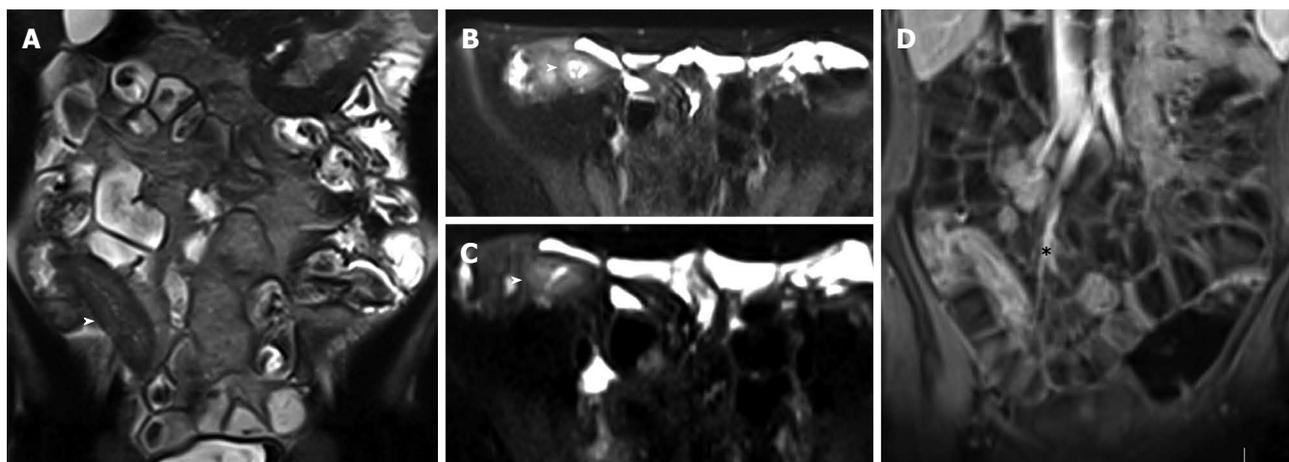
Thirteen years old male with active Crohn's disease. Coronal T2-weighted image (A), and transverse fat saturation T2-weighted images (B and C), show mural thickness and increased mural signal (arrowhead in B, C, and D) in the terminal ileum due to edema. Coronal post-contrast T1-weighted fat-suppressed image (D) at the same level shows mural stratification (asterisk).
